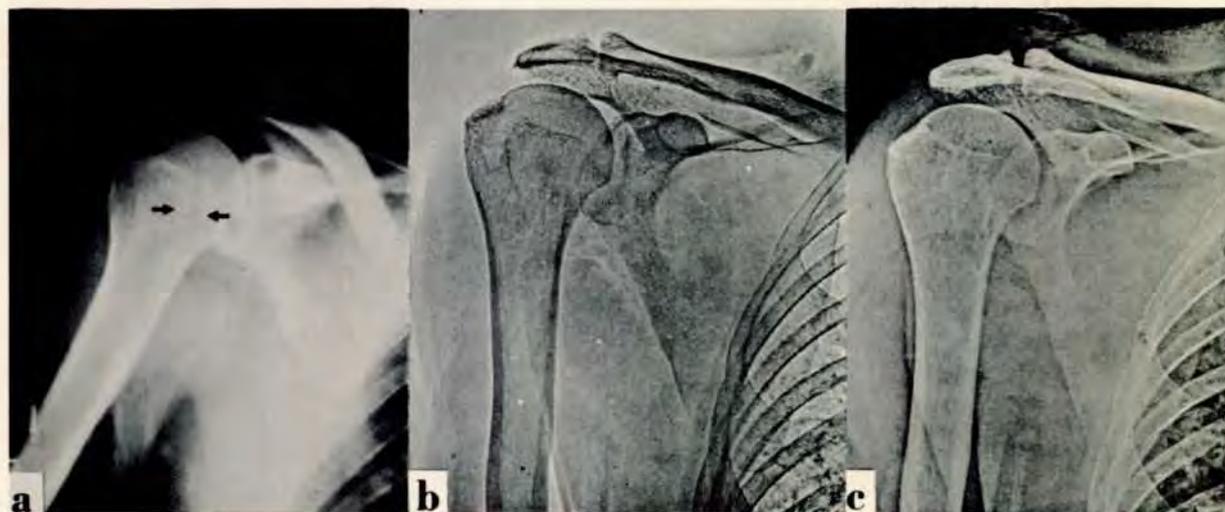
(a) Conventional roentgenogram demonstrates subtle circular cystic formation in R humeral head of diver. Finding is not evident on either (b) positive or (c) negative xeroradiogram. Note, however, better bone detail on positive xeroradiogram in comparison with negative one.
